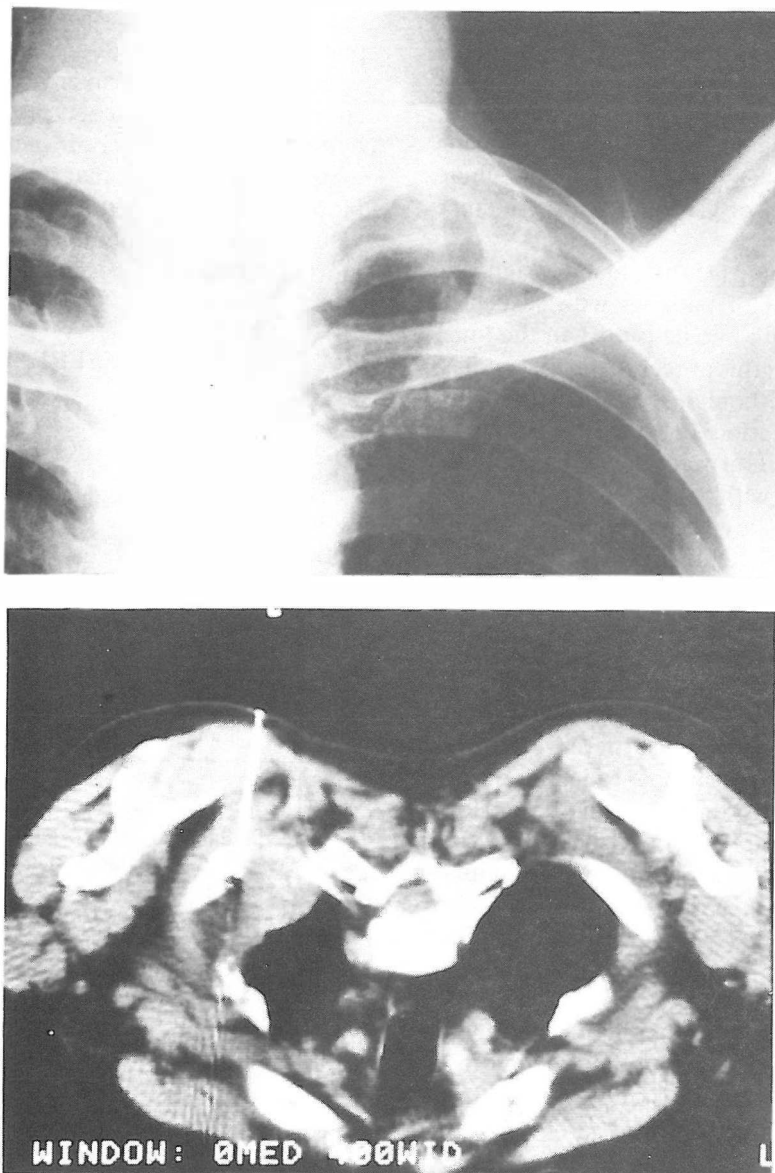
A 75-year-old man with shoulder pain. A. Posteroanterior chest radiograph demonstrates asymmetric apical cap in the left side. B. Prone CT during biopsy shows needle tip in apical mass. Pathologic examination revealed squamous cell carcinoma. CT is the best procedure for demonstrating early superior sulcus tumors.
